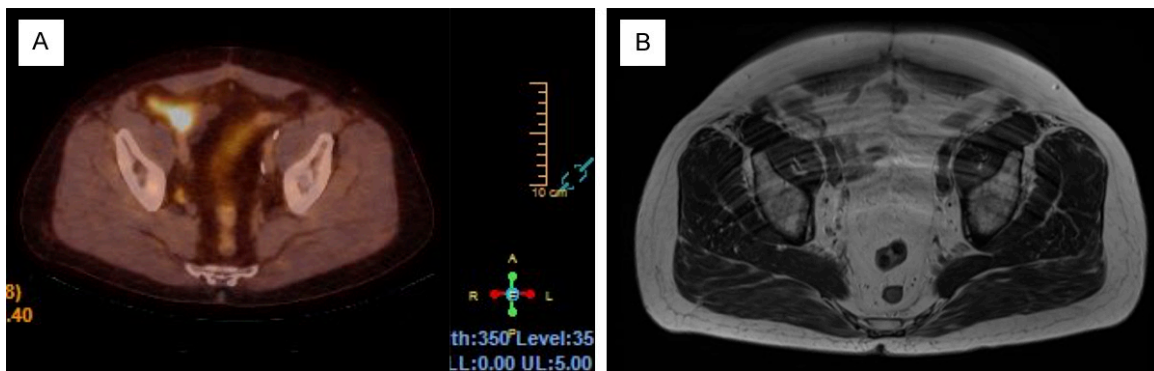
^{18}F -PSMA-1007 PET/CT and MRI (T2-weighted) of a 66 years old patient after radical prostatectomy one year ago. PSA level at the time of the study was 1.18 ng/ml. A. ^{18}F -PSMA-1007 accumulation in the right side lymph node, in front of the right internal iliac artery, confirming metastasis in regional lymph nodes. B. Pathologic lymph node was detected on MRI as nonspecific. After the studies, the patient received radiation therapy for the lymph node.
